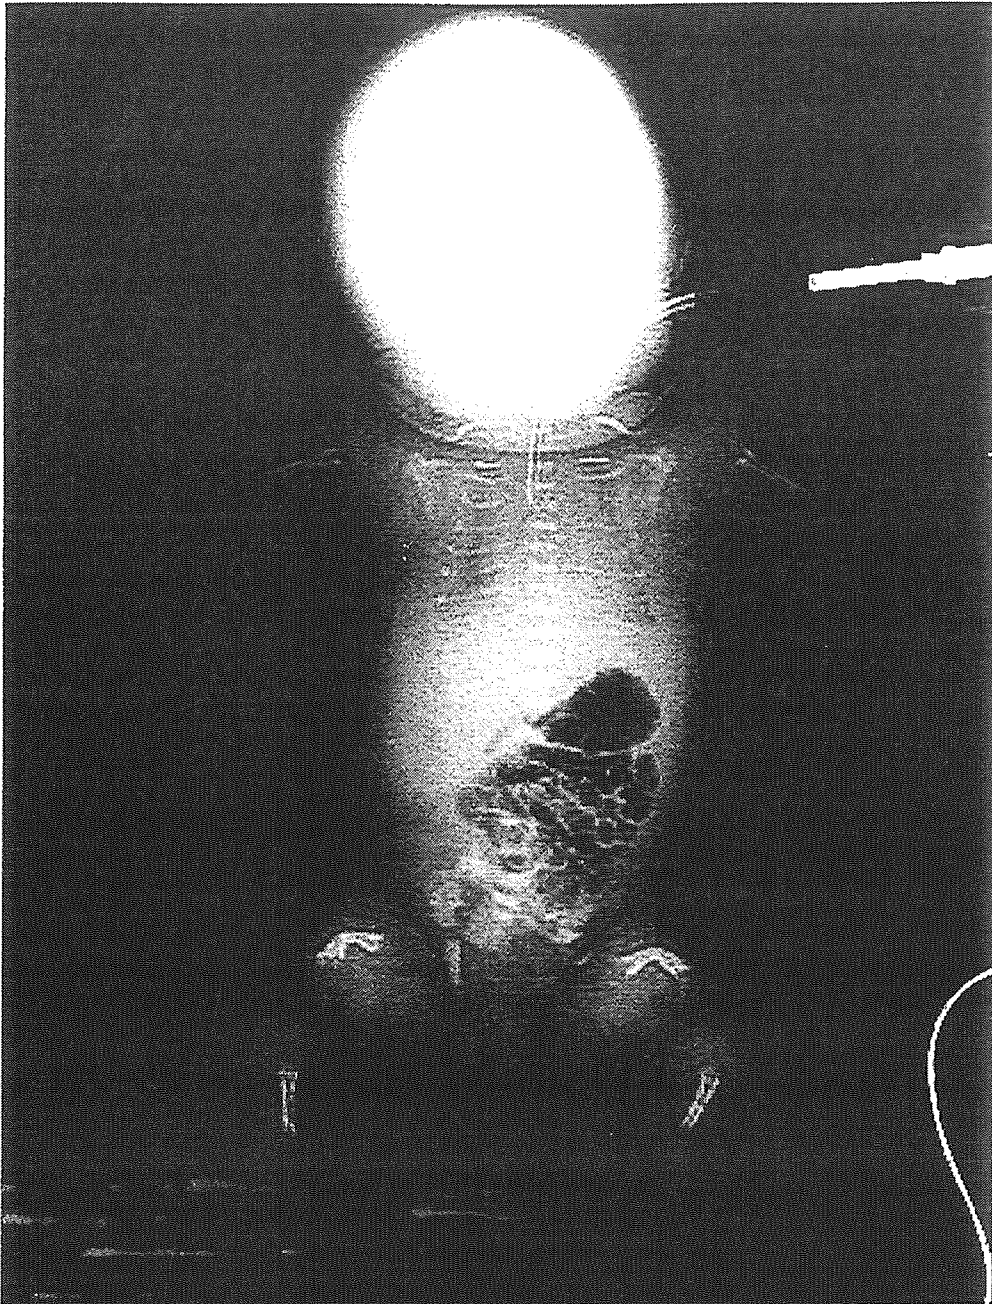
Radiographic findings. Marked retardation of skeletal ossification, poor mineralization of the skull, shortness and bowing of the poorly mineralized tubular bones, marked flattening of vertebral bodies, narrow chest with short hypomineralized ribs and cupping and fraying of metaphyses of long bones. These findings are consistent with a phenotype of severe form of hypophosphatasia, that is, perinatal (lethal) type
